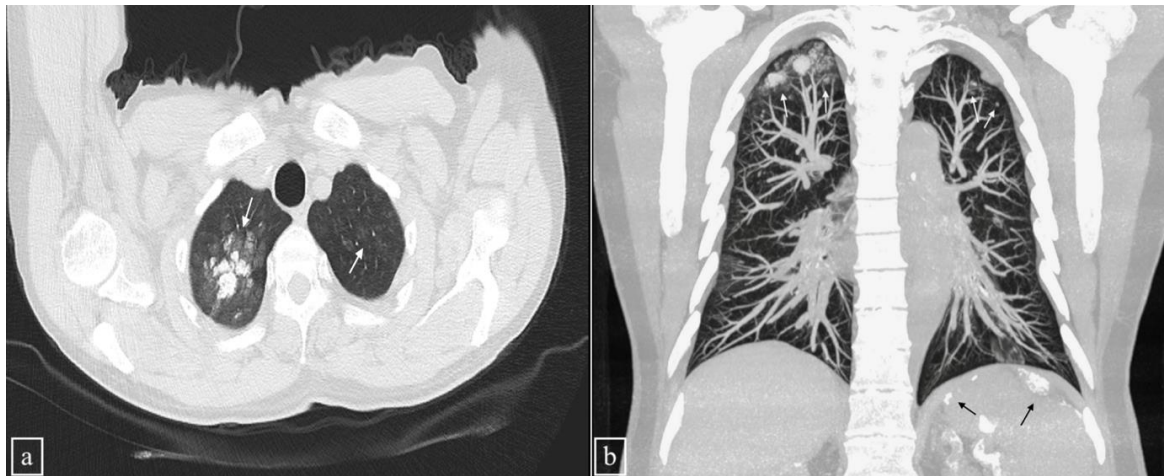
Axial chest CT section (a) and coronal MIP image (b) shows centrilobular, patchy ground-glass opacities and calcified nodules in both lung apices, more prominent on the right (white arrows). Splenic capsule calcifications can be seen in the image on b (black arrows).
